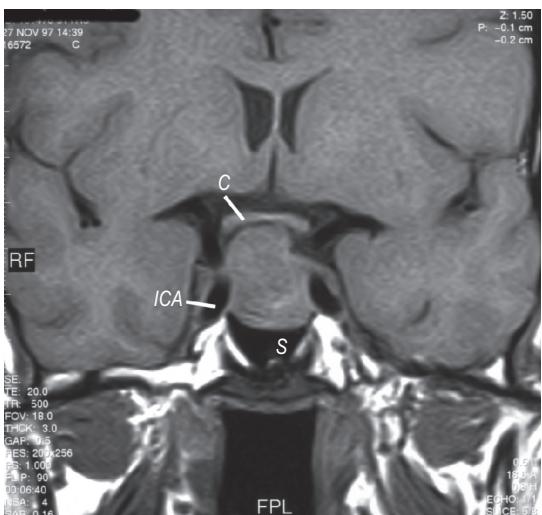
(see left) Contralateral bitemporal homonymous hemianopia (top panel) caused by interruption or damage to the nasal retinal fibres decussating in the optic chiasma (middle panel). A common cause of such deficits is pituitary tumours (bottom panel). Radiograph: coronal MR image of the sellar region in a 31-year-old patient who presented with bitemporal hemianopia. A large pituitary tumour can be seen compressing the optic chiasm (C). S, sphenoid sinus; ICA, internal carotid artery. (Radiographic image courtesy of Prof. T. Chakera, Royal Perth Hospital.)
